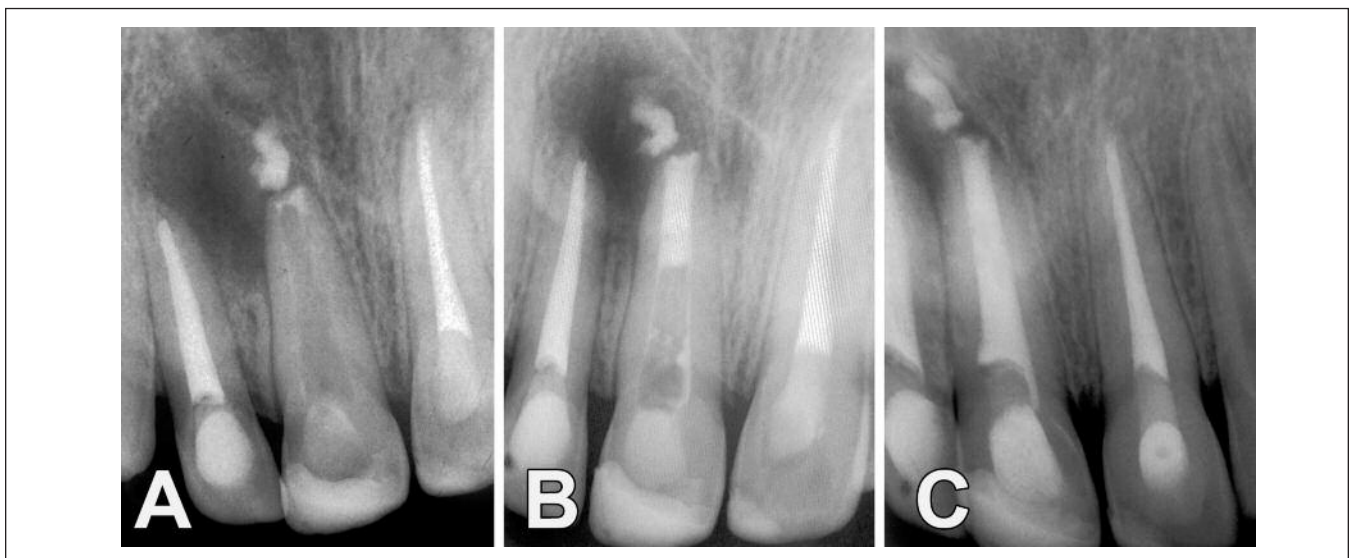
A. Radiographic view of extruded MTA. B. Completion of MTA apical barrier. C. Radiographic view of completed root canal obturation.
